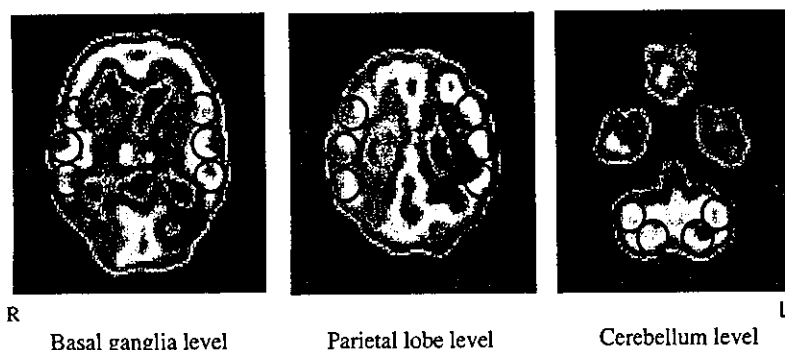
ROI settings. Circular ROIs, 20 mm in diameter, were placed over the cortex at the levels of the basal ganglia (lower MCA territory), parietal lobe (upper MCA territory), and cerebellum in the SPECT and PET images of each patient.
